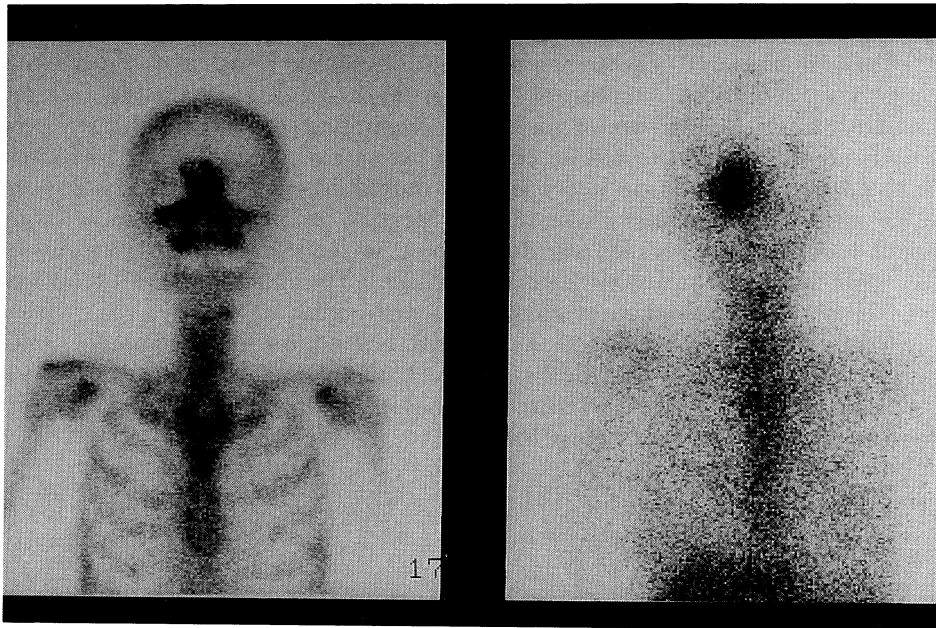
Bone scintigraphy disclosed increased activity in the right maxilla. <sup>67</sup>Ga scintigraphy disclosed increased activity in the right maxillary region. Neither examination showed any regional or distant metastasis.
